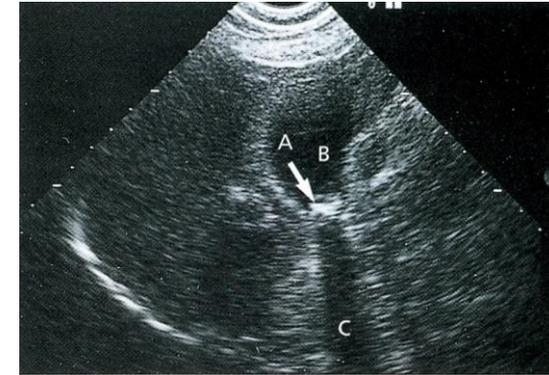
Ultrasound is the optimal initial investigation for gallstones. The scan shows a typical gall stone (A) in the gall bladder (B). The acoustic shadow (C) cast by the stone is typical.
